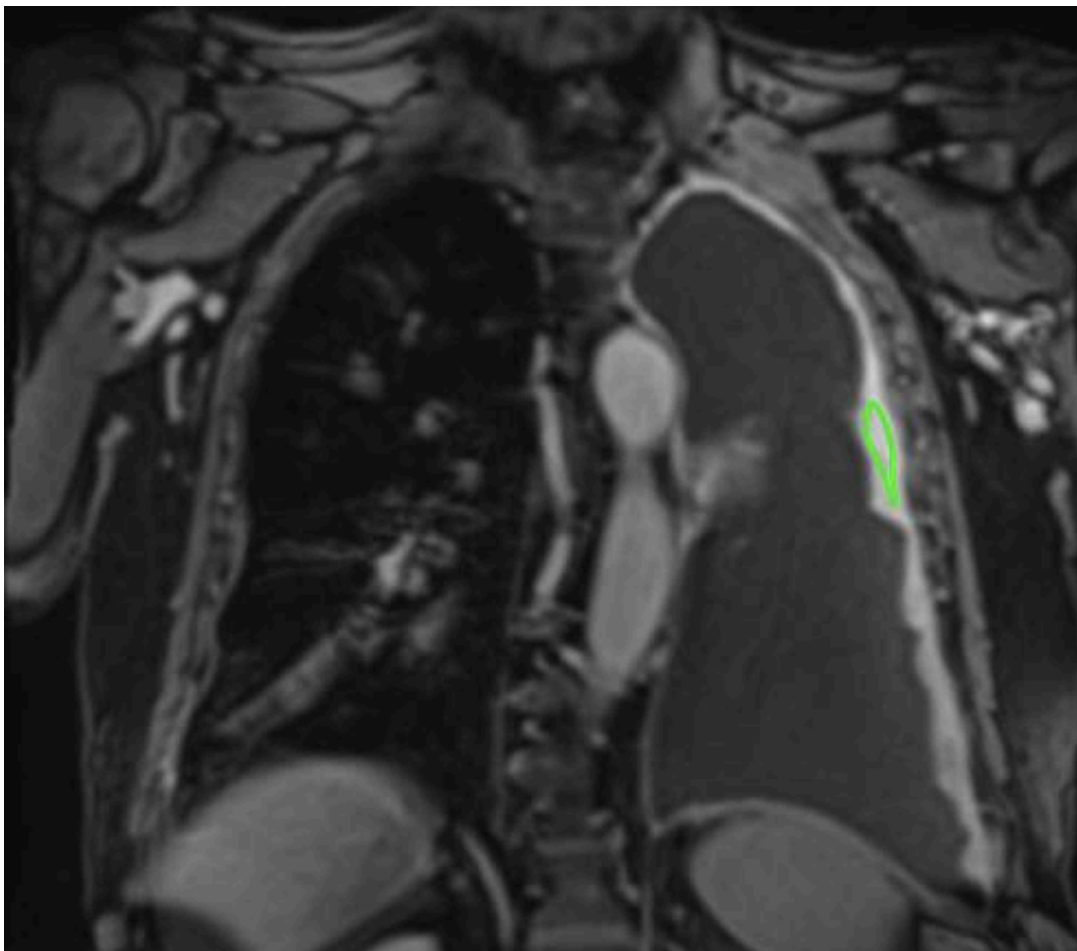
Example of ROI placed on macro-nodular pleural disease at contrast-enhanced MRI
